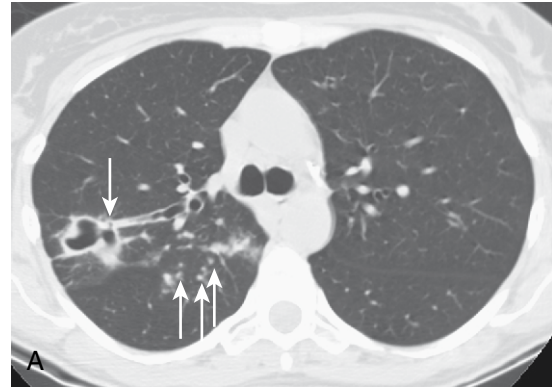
Cavitory tuberculosis. Minimal intensity projection CT image of a patient with reactivation tuberculosis shows a thick-walled cavity (*arrow*) in the posterior segment of the right upper lobe.
